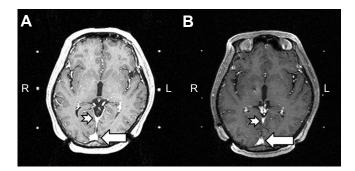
T1-weighted double-dose gadolinium-enhanced brain MRI scans of a 54-year-old male patient treated with levodopa for 12 years, presenting with aggravated stating hesitancy, turning hesitancy, and whole body dyskinesia.
